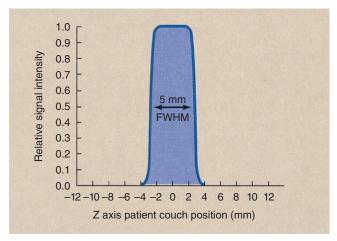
The section sensitivity profile (SSP) for a conventional computed tomography imaging system is nearly rectangular and is identified by its full width at half maximum (FWHM).
